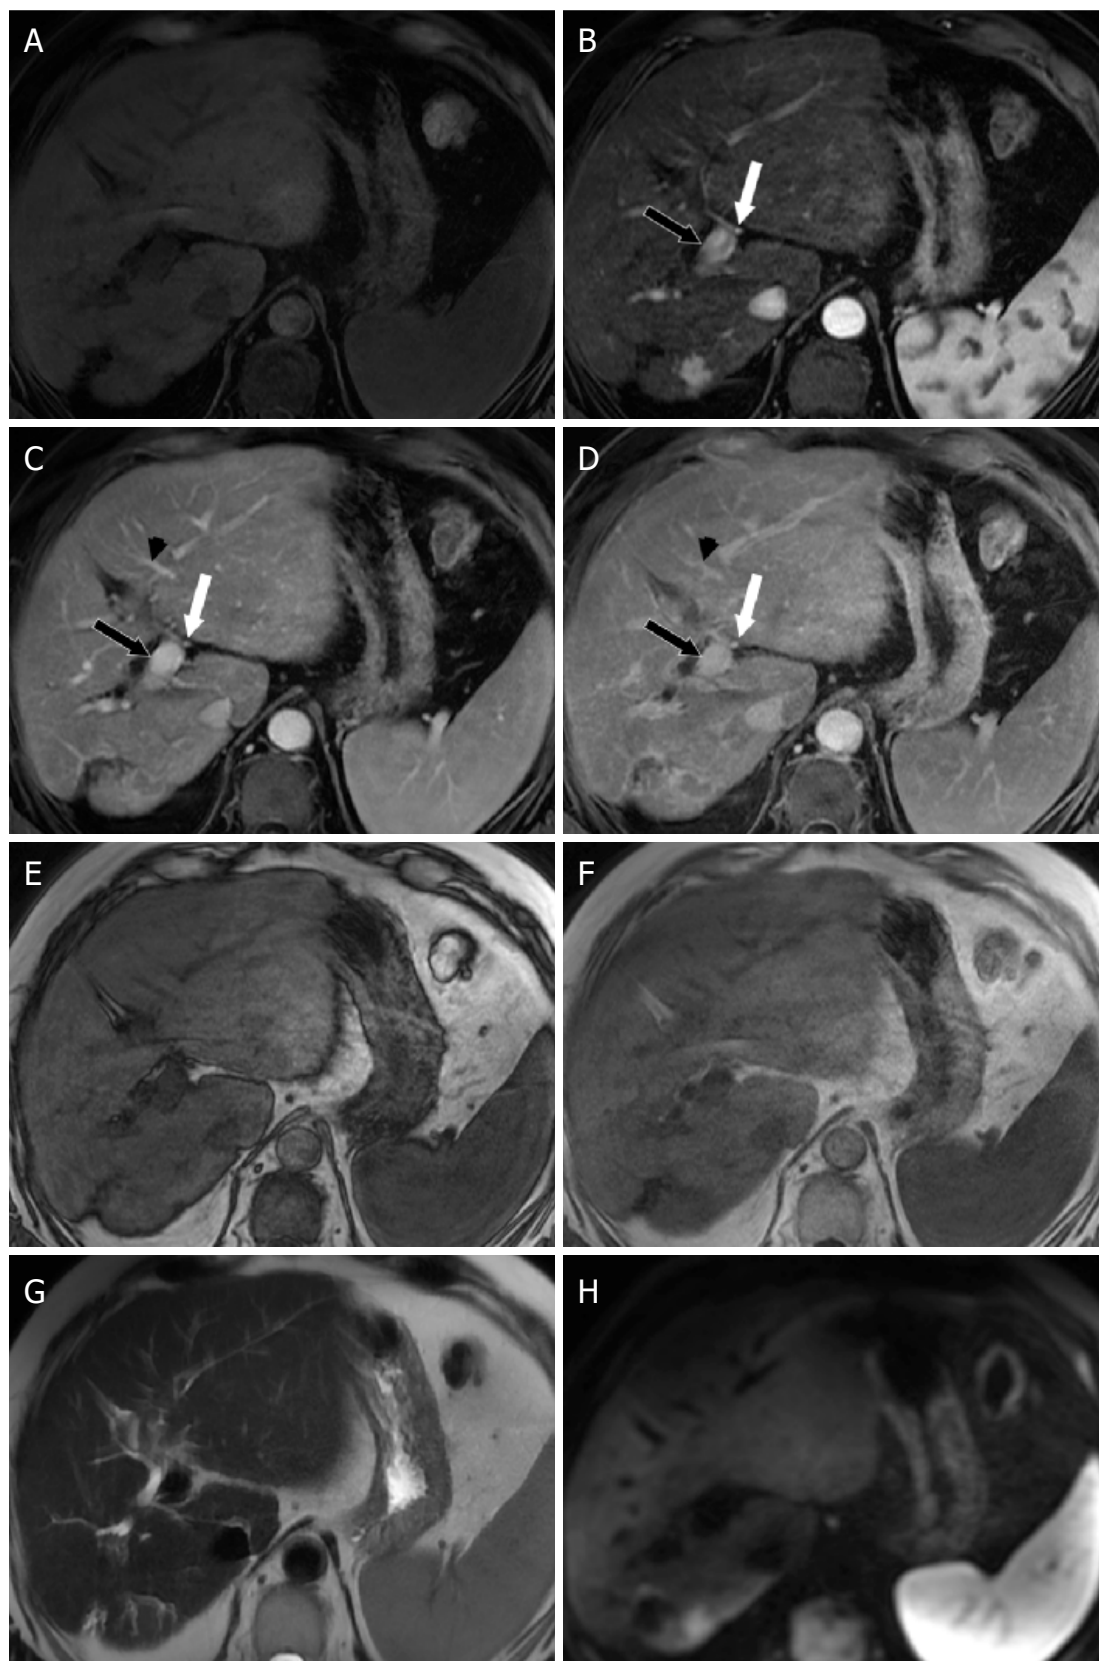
MRI for Evaluation for HCC. Axial MR images of an exam meeting minimum technical requirements for evaluation of HCC. Axial T1-weighted fat saturated images should be obtained pre-contrast (A), and following intravenous contrast during the hepatic arterial (B), portal venous (C), and delayed (D) phases. Additional required imaging sequences include opposed phase (E) and in phase (F) T1-weighted images and T2-weighted images (G). Diffusion weighted imaging (H) is not required, but is suggested if available. White arrow: hepatic artery; Black arrow: portal vein; Black arrowhead: hepatic vein. MRI: magnetic resonance imaging; HCC: hepatocellular carcinoma
